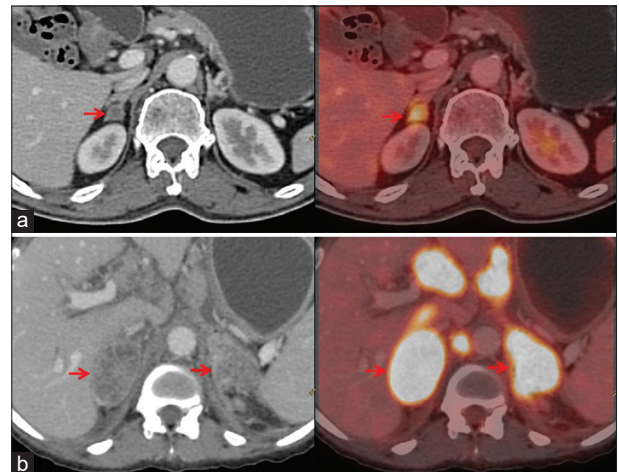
Metastases. (a) A 63-year-old male having squamous cell carcinoma of the lung having right adrenal metastasis on positron emission tomography-computed tomography (PET/CT) scan. CT and corresponding PET/CT images showing a metabolically active hypodense nodule in the right adrenal gland. (b) A 35-year-old female having gallbladder carcinoma on PET/CT scan. CT and corresponding PET/CT images showing metabolically active heterogeneously enhancing lesions of the bilateral adrenal gland. Images also showing metabolically active abdominal and retroperitoneal lymph nodes
